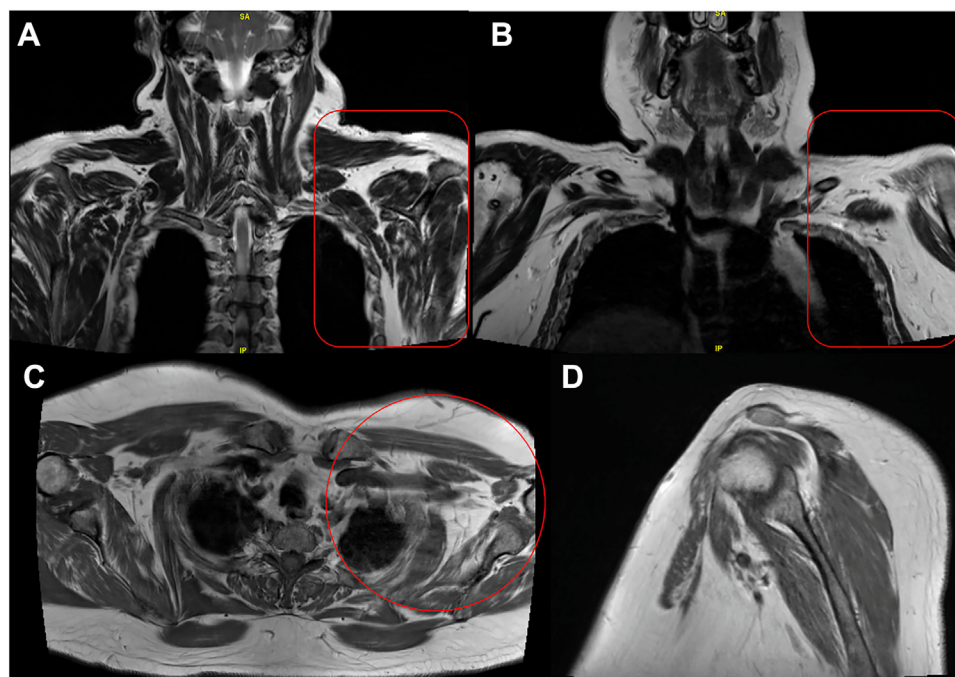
57 yoM with 6-month history of brachial pan-plexopathy following COVID-19 infection. MRI demonstrates asymmetric decreased bulk of multiple muscles around left chest wall and shoulder with varying nerve distributions consistent with chronic
